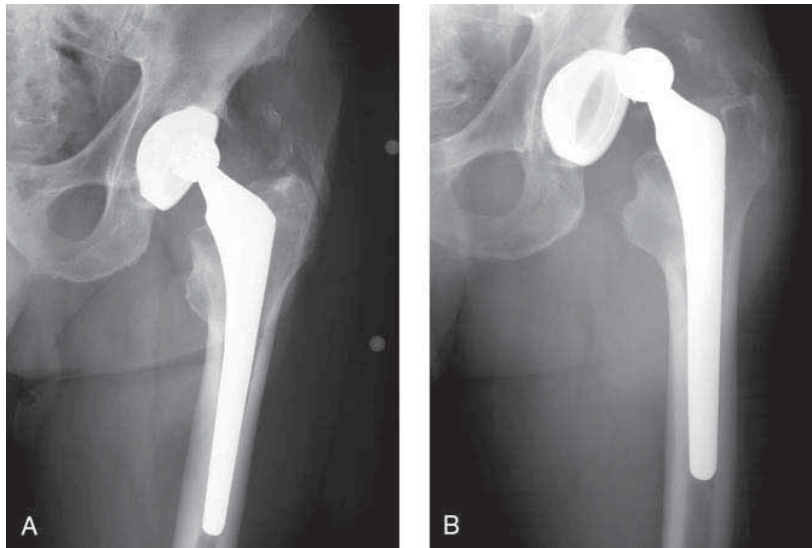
Dislocation following total hip arthroplasty can occur at any time. A, AP radiograph made 12 years following a hip arthroplasty. Polyethylene wear is made evident by eccentric seating of the femoral head inside the acetabular liner. B, The polyethylene wear was deemed to be responsible for the dislocation in this patient.
